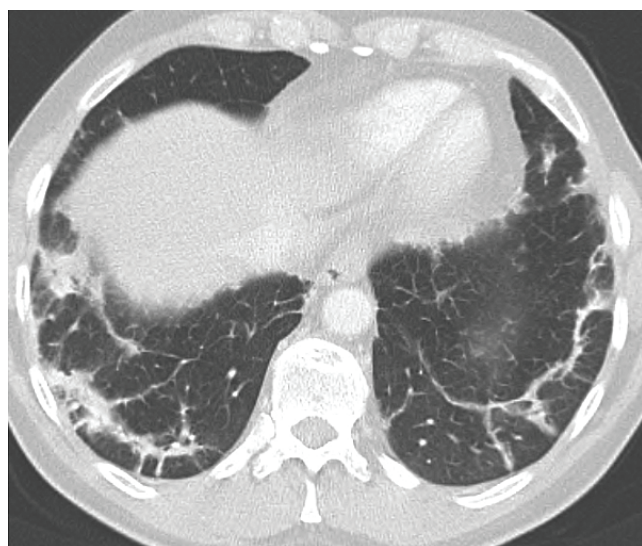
Adverse event: interstitial pneumonitis seen on computed tomography imaging.
